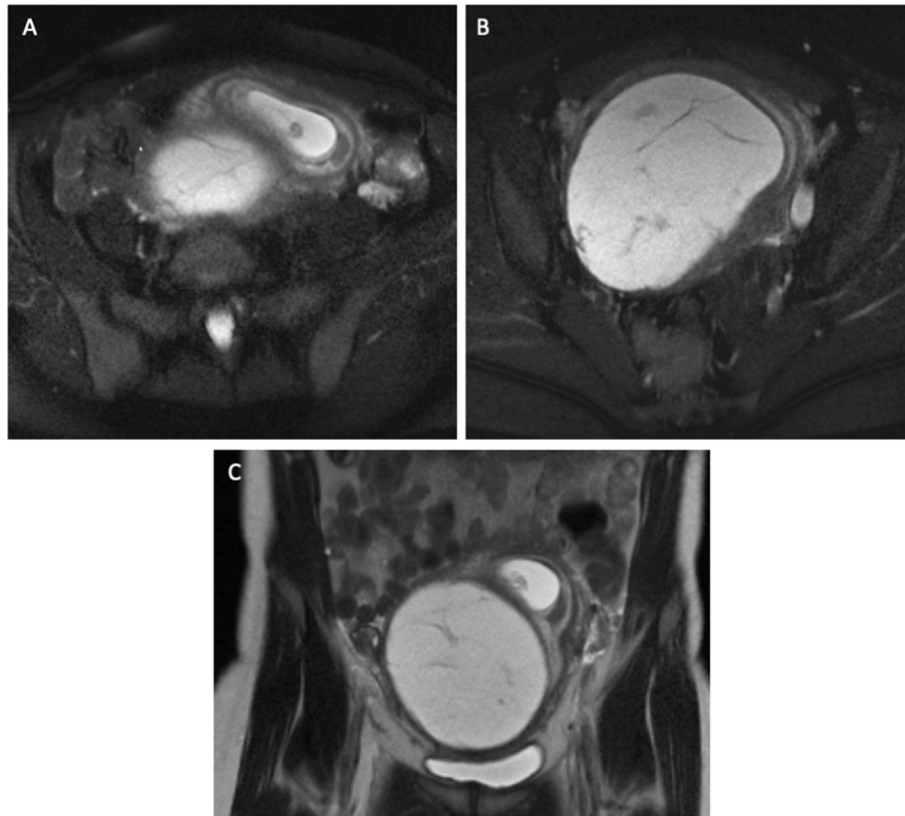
Axial T2-weighted, fat-saturated MR images show the early gestational sac (A) as well as a large, predominately cystic submucosal mass with nodular internal septations (B). Note the relationship of the mass to the gestational sac on coronal T2 weighted image (C).
